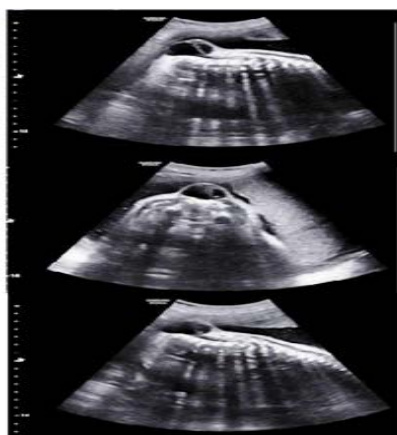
Ultrasonography showed cystic lesion with internal septa adjacent to the posterior and lower part of spine, recommended for myelomeningocele.
